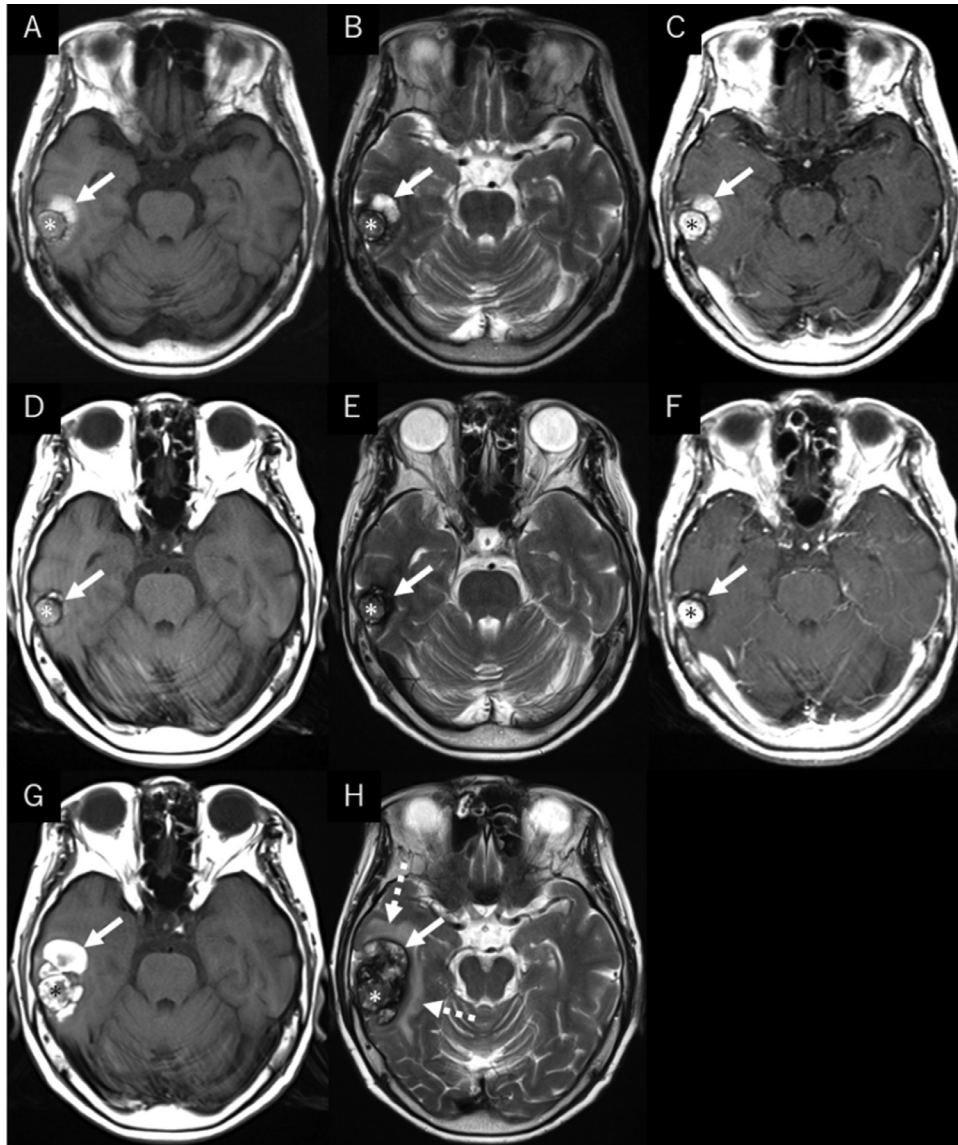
Non-contrast axial T1- (A, D, G), T2- (B, E, H), and contrast enhanced (C, F) T1-weighted magnetic resonance images performed 3 (A-C), 42 (D-F), and 126 days (G, H) after the initial presentation showing the central part of the right temporal lesion appearing inhomogeneous intensity on both T1- and T2-weighted sequences with heterogeneous enhancement. The perilesional hemorrhagic regions appear hyperintense on both T1- and T2-weighted sequences, showing temporary regression (D-F) followed by marked enlargement with an emergence of extensive perifocal brain edema during the next 123 days (G, H). Arrow: perilesional hemorrhagic regions; Asterisk: central part of the lesion; Dashed arrow: perifocal brain edema.
